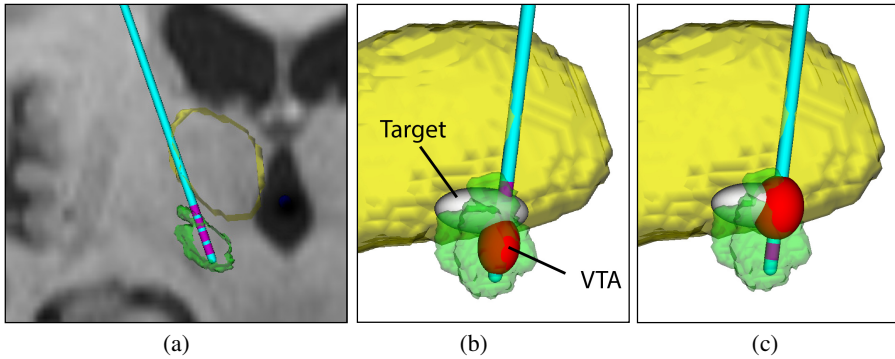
Image based efficacy estimation of deep brain stimulation (DBS) treatment. Brain atlas was registered to the patient’s MRI (a; the thalamus (yellow) and subthalamic nucleus (green) contours are presented). The electrode was identified on the postoperative CT image and transformed to MRI coordinates (a). Then, for each stimulation setup, volume of tissue activated (VTA, red) was computed and compared with a preferred therapeutic *target* area (grey). Our results show that stimulation setups that are associated with small overlap (b) are in general less effective in comparison to setups that yield large overlap (c).
